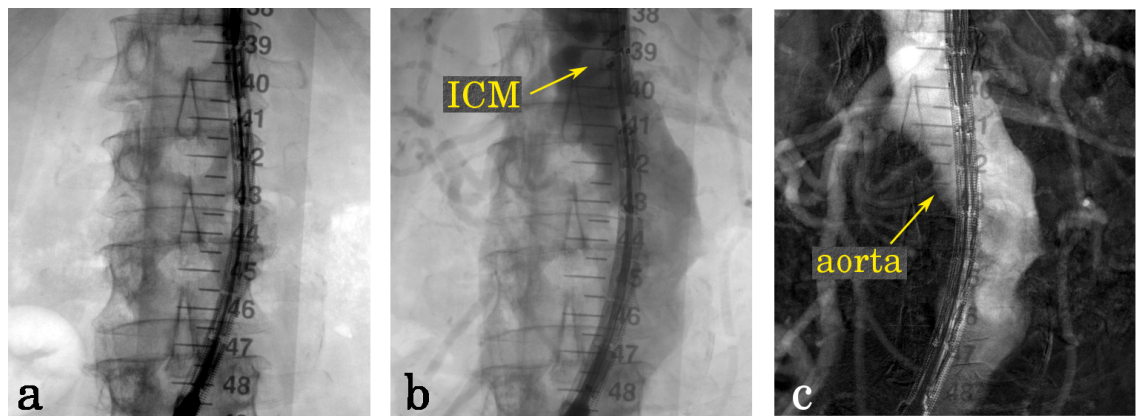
Enhancing vascular visualisation using iodinated contrast medium (ICM) and high dose X-ray. a) Contrast-free mask image, b) example angiography image showing ICM inside parts of the aorta, and c) the produced DSA image showing the enhanced aorta.
